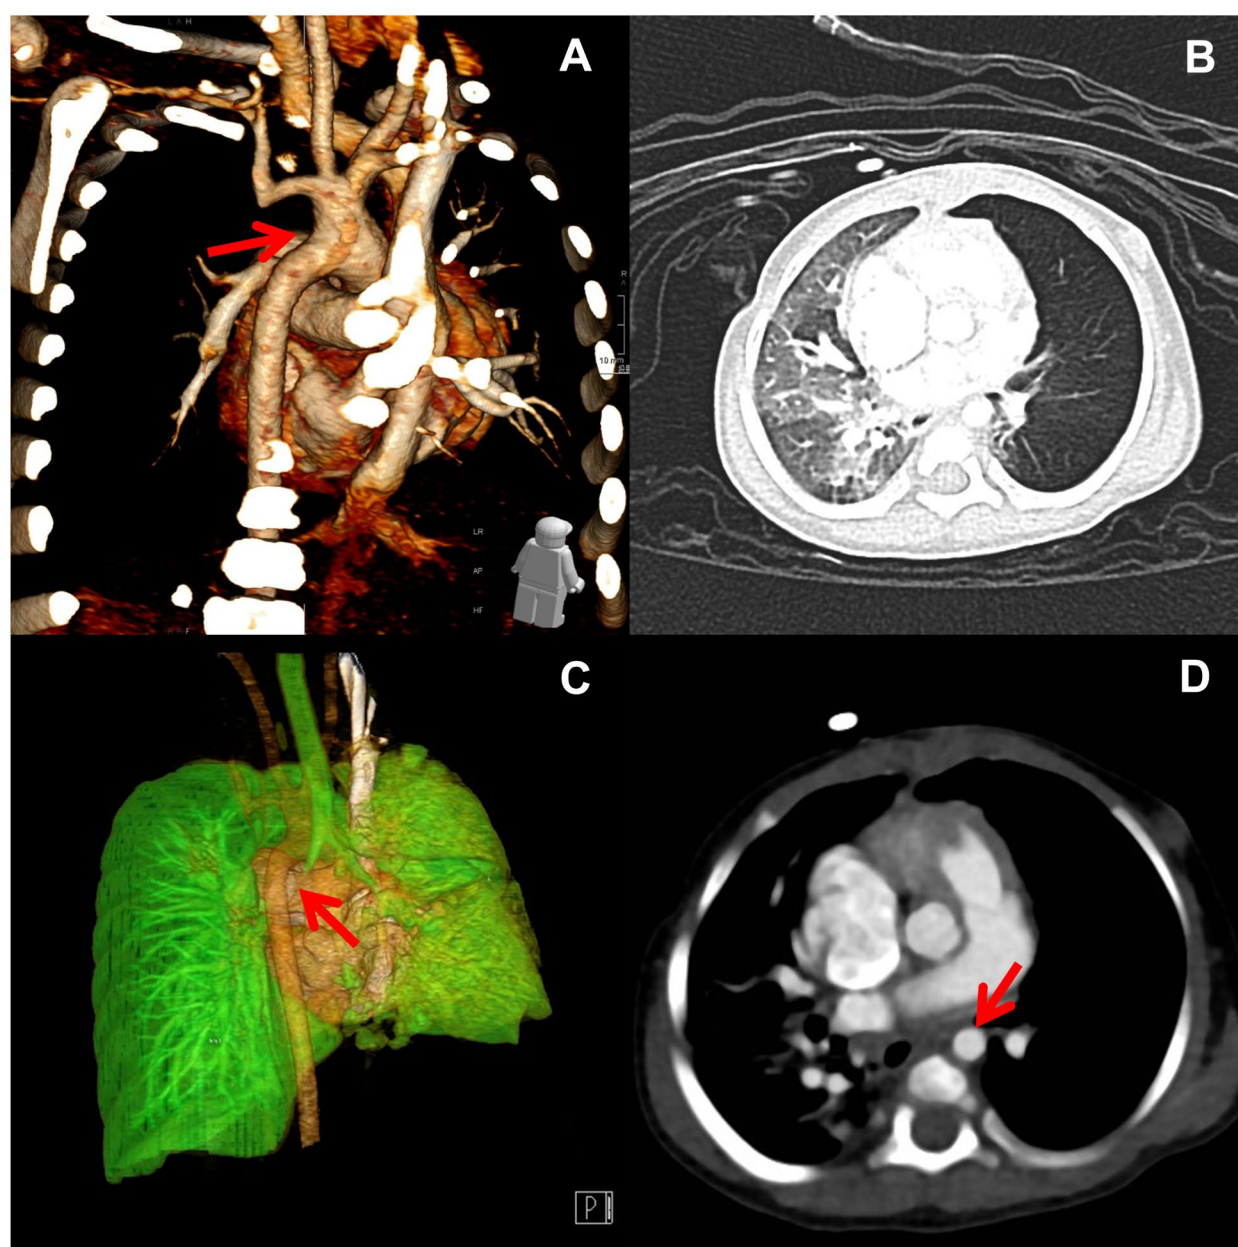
Preoperative imaging data. (a) The 3D reconstruction image of the heart and major blood vessels in the pediatric patient following CoA surgery (the arrow indicates the site of aortic reconstruction); (b) The chest CT images of the pediatric patient obtained upon hospital admission; (c) The 3D reconstruction image of the child patient's airway (the arrow indicates the region of airway stenosis); (d) Enhanced CT image of the child's heart (the arrow indicates the anteriorly displaced aorta)
